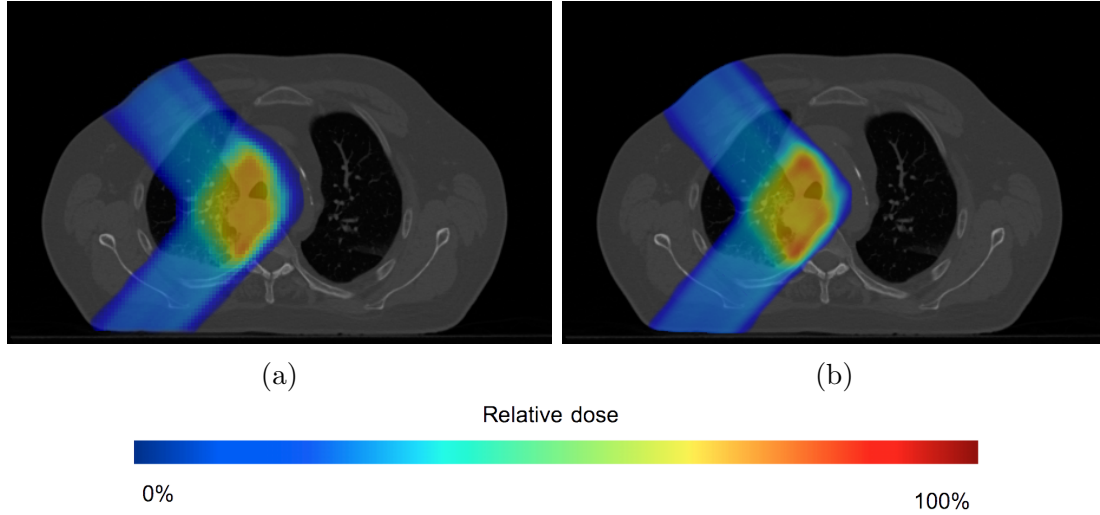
Dose distributions computed in *ProtonMachine* (4.6a) and in MSPT (4.6b) overlaying the patient CT image (transverse plane located near the middle of the tumor).
